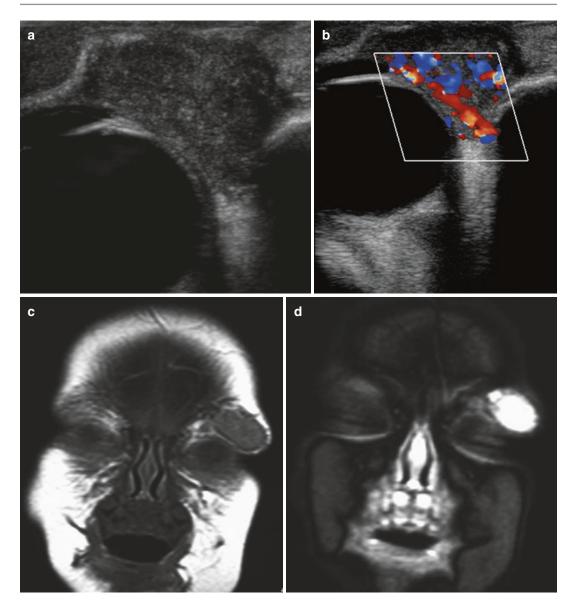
Proliferative haemangioma. Grey scale (a) and colour Doppler (b) ultrasound demonstrates a highly vascular mass at the lateral aspect of the eyelid extending
